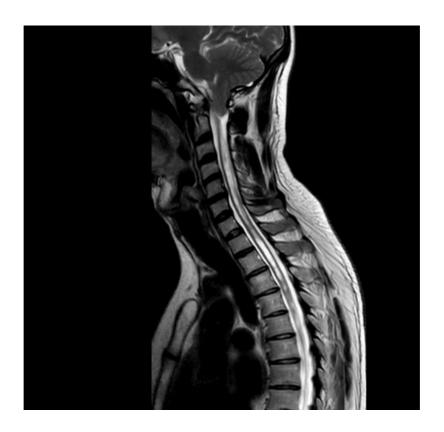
Sagittal T2-weighted MRI sequences of the cervical spine of case 1 with secondary cough headache. Imaging shows an Arnold-Chiari malformation type I with approximately 18mm tonsillar descent relative to the foramen magnum and a large syrinx from C2 to T5. Irrespective of whether primary or secondary, the disorder remains COX-2 responsive with etoricoxib.
